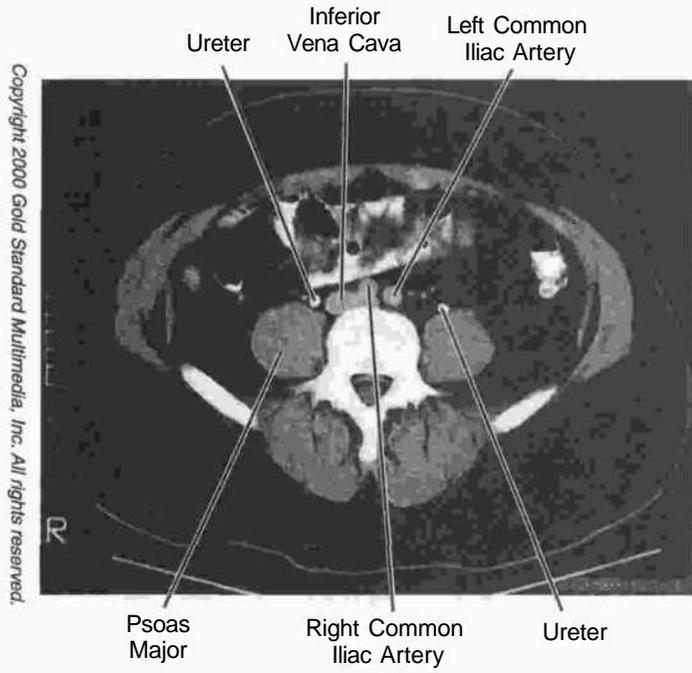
Figure IH-3-43. Abdomen: CT, L4
